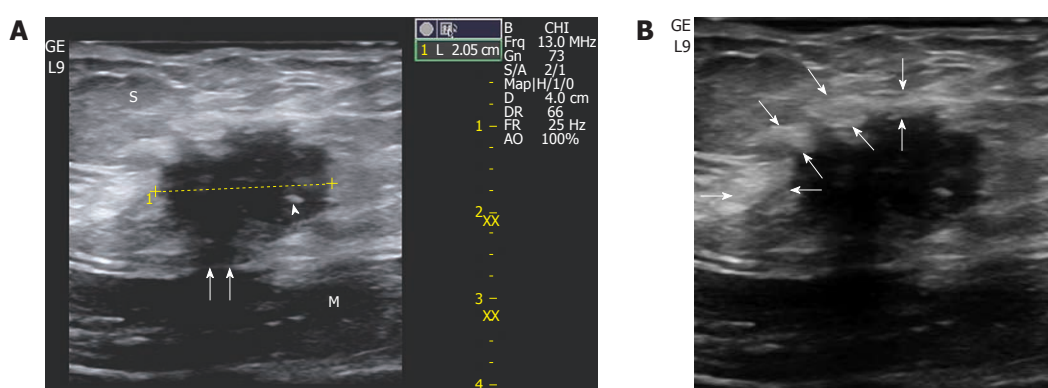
A 32-year-old woman with 6-mo of cyclic pain two years after a cesarean delivery. A: A small (2 cm) scar endometrioma is displayed at sonography located in the subcutaneous fat (S) with typical features: a roundish nodule, hypoechoic with fibrotic spots (the thick one is indicated by a white arrowhead), spiculated margins infiltrating the sheath (white arrows) of the rectus abdominis (M); B: An inflammatory hyperechoic ring (between white arrows) circumscribes almost the entire endometrioma.
